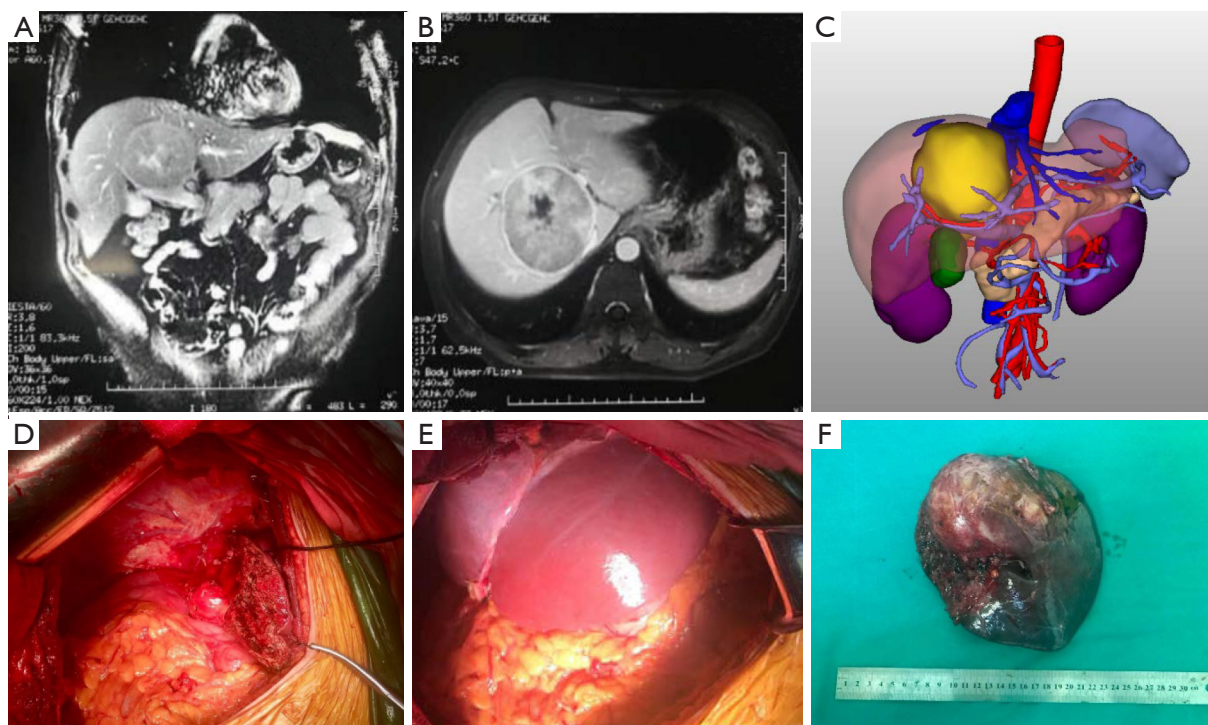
A representative set of MRI, three-dimensional imaging, and operative photographs of a 45-year-old male with a solitary huge BS-HCC located between the left and right hemilivers. MRI (A,B) and three-dimensional imaging (C) show a solitary huge lesion located in segments 4, 5, and 8 (largest tumor size: 11.0 cm). The preoperative AFP was 48.9 ng/mL. This patient underwent curative extended right hepatectomy (D-F) on November 02, 2017, and was still alive and recurrence-free at the last follow-up on July 20, 2021. MRI, magnetic resonance imaging; BS-HCC, balloon-shaped hepatocellular carcinoma; AFP, alpha-fetoprotein.
